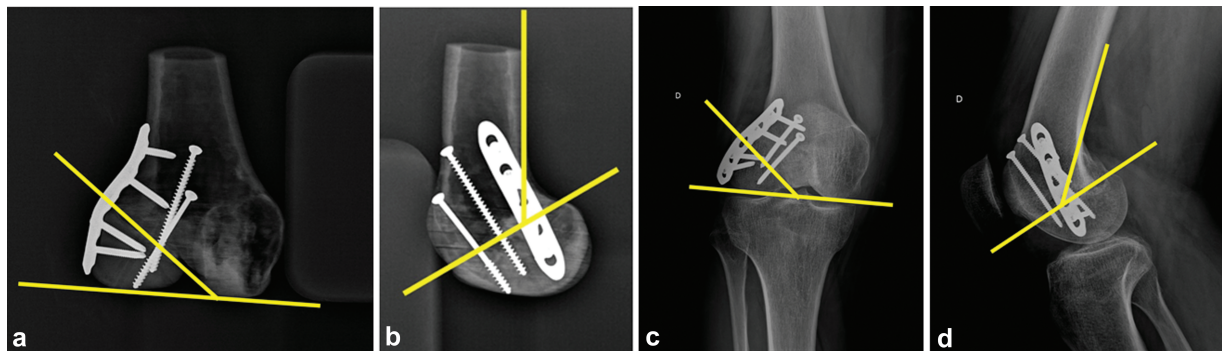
Anatomical references on the AP and Lateral view radiographs with the tangential tracing of lines on the landmarks and the formation of angles to measure the position of the implants.
